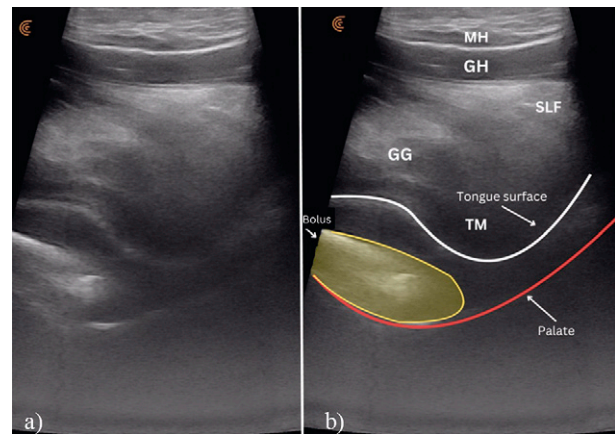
Ultrasonographic images of the oral cavity and pharyngeal region: a) Baseline image showing the anatomical structure without labels.; b) Labeled structures include the mylohyoid muscle (MH), geniohyoid muscle (GH), genioglossus muscle (GG), sublingual fat (SLF), tongue mass (TM), lingual surface, and palatal surface. The lingual surface is marked with a white line and the palatal surface with a red line, highlighting reference points essential for evaluating tongue-palate contact during swallowing.
